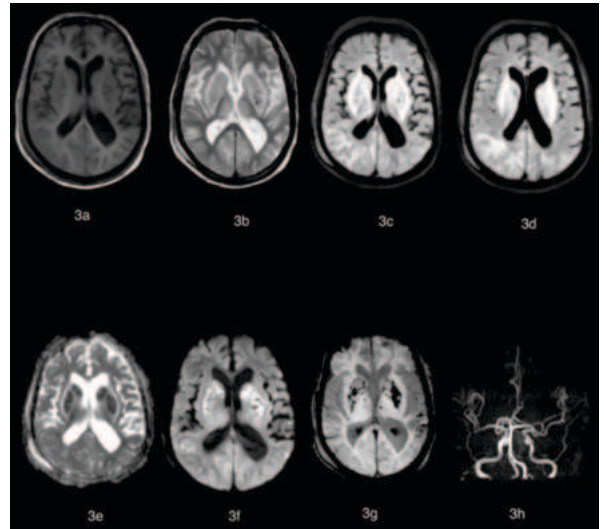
(a-h) MRI Brain with MR angiography brain a) Axial section showing normal intensity basal ganglia and thalamus; b) & c) T2 and FLAIR hyperintense areas with lentiform rim sign seen involving the basal ganglia and thalami; d) FLAIR hyperintense areas in bilateral periventricular region; e) & f) Areas of restricted diffusion on DWI and ADC drop involving the bilateral basal ganglia and thalami; g) SWI sequence showing Blooming in corresponding areas; h) MR Angiography brain showing insignificant bilateral MCA atherosclerotic disease.
